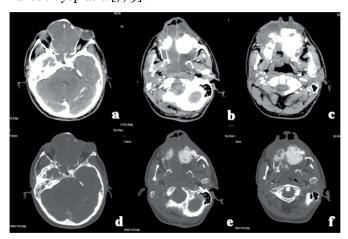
Computed tomography scan after injection of contrast medium. Axial images evaluated (a–c) with soft tissue window and (d–f) with bone tissue window (d, e, f) revealed tumor with a major component like soft tissues, central calcification/ossification, originating in the left upper quadrant of the maxilla and invading nasal cavity, ethmoid cells, sphenoidal and frontal sinuses, the right upper quadrant of the maxilla, left alveolar process, hard palate and the base of the orbit without involvement of the orbital adipose tissue.
